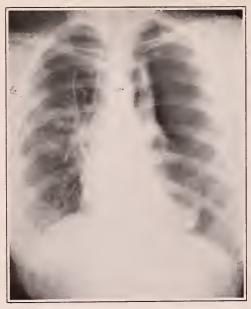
Case VII, roentgenogram of Nov. 20, 1930, showing left lung collapsed, but with herniation of the mediastinum into right thorax (a), and definite areas of infiltration in the right lung field, (b).
